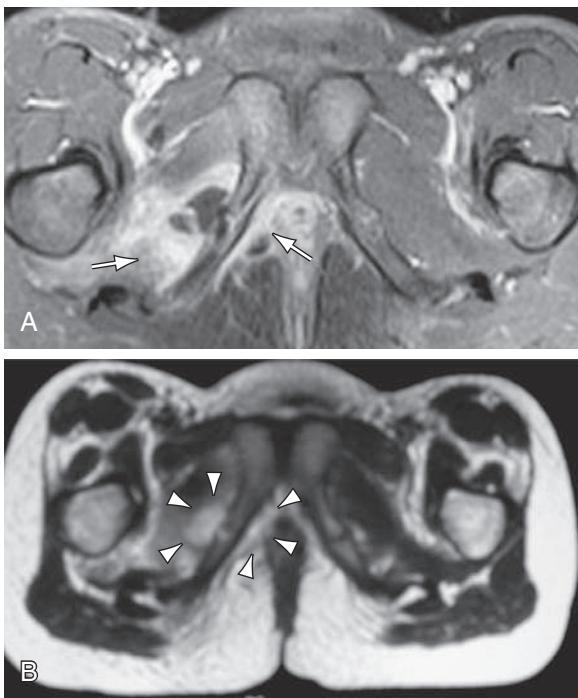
MRI of an 8-year-old female with acute pelvic hematogenous osteomyelitis. A, Axial T1-weighted contrast-enhanced MRI with fat saturation reveals a nonenhancing fluid collection adjacent to the inflamed pubic synchondrosis. B, The fluid collection appears hyperintense on the corresponding T2-weighted image (arrowheads). In addition, a contrast enhancement within the adjacent internal obturator muscle is seen (arrow), indicating acute pelvic hematogenous osteomyelitis with complicating adjacent abscess formation and soft tissue inflammation. (From Weber-Chrysochoou C, Corti N, Goetschel P, et al. Pelvic osteomyelitis: a diagnostic challenge in children. *J Pediatr Surg*. 2007;42:553–557.)
